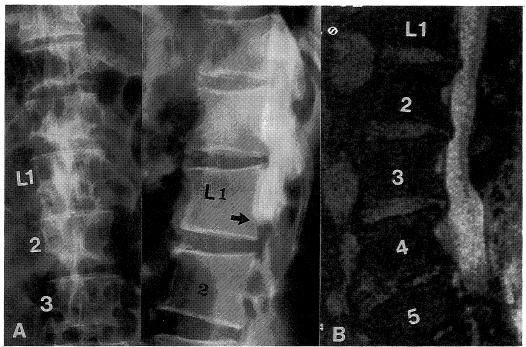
A myelography of 56 year old woman who had radicular symptoms of both lower extremities, urinary incontinence and a neural intermittent claudication, showed the complete filling defect of the contrast coulmn in the lower levels than the portion of 2nd lumbar spine (A). A decompressive surgery and a embracement of the cauda equina with a silicone rubber was performed. Six years later after the operation, she was examined with a MRI as a follow-up study. The MRI demonstrated no signs of restenosis due to the indentation of the hypertrophic scar formation (B).
